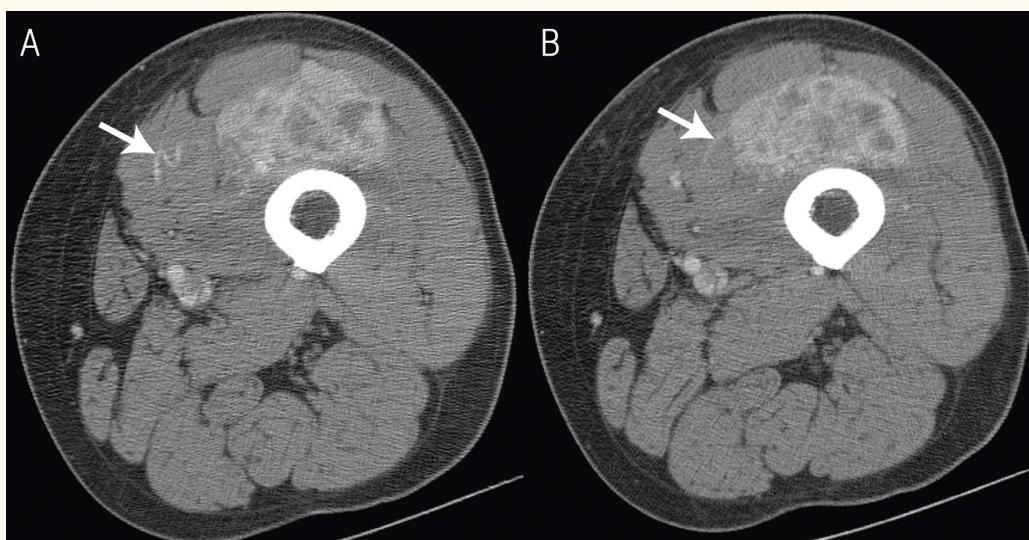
Contrast-enhanced computed tomography images from a 44-year-old man with renal cell carcinoma showing muscle metastasis with visible feeding or draining vessels in the left quadriceps (arrows). This is also an example of a heterogeneous pattern of enhancement.
